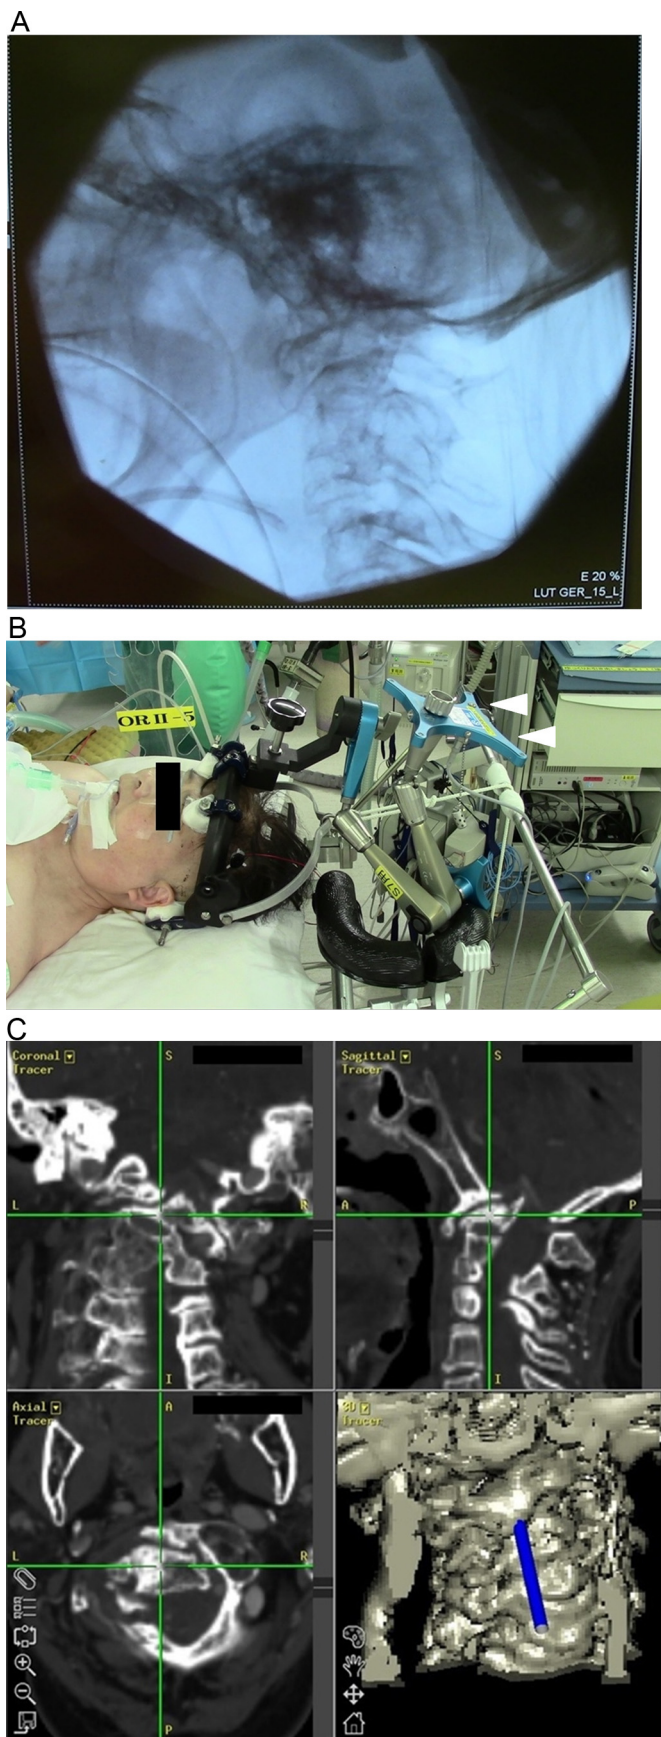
(A) Preoperative traction under general anesthesia failed to reduce the basilar invagination. (B) The preoperative setting of the patient. The reference arc of the navigation system (the arrow head) was attached to the halo ring via a metal connector. (C) The intraoperative CT navigation images. The tip of the probe was visualized on the CT navigation images.
